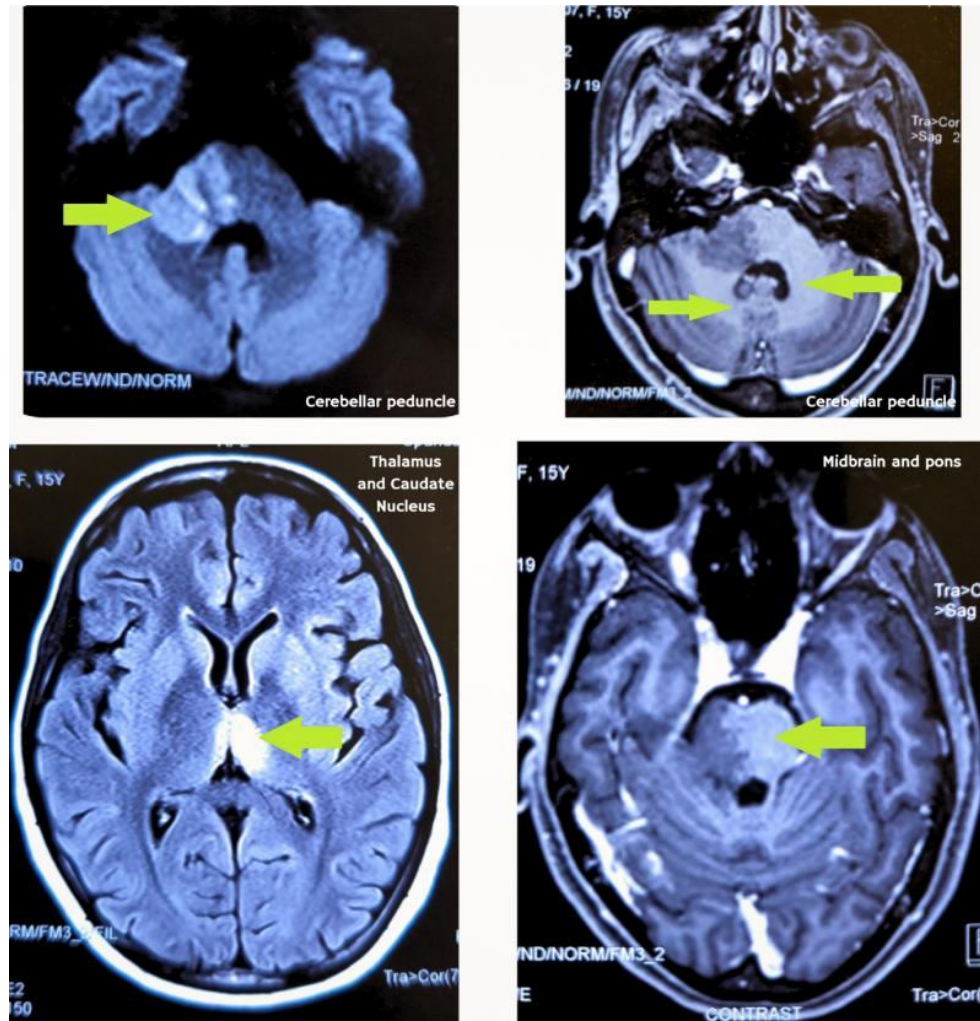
MRI Brain showing lesions in thalamus, caudate nucleus, cerebellar peduncle and brain stem(arrow).
